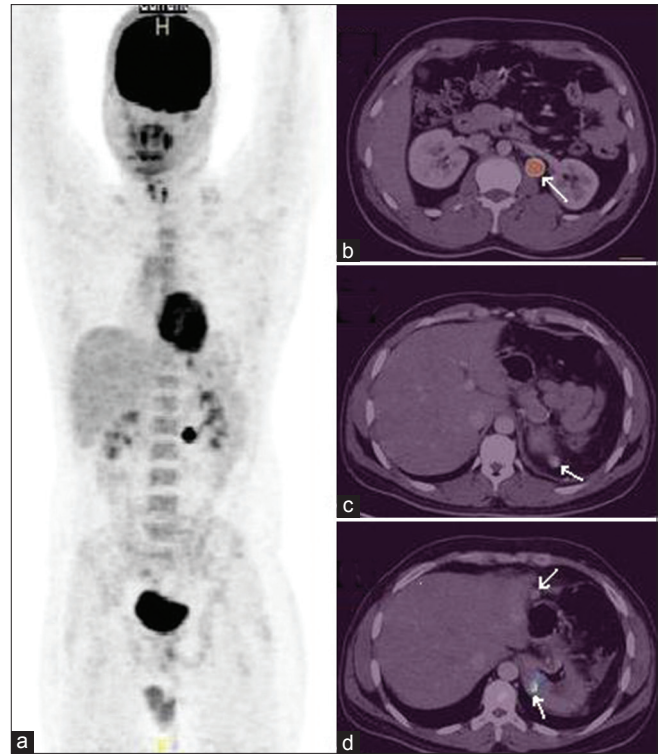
Whole body fluorodeoxyglucose-positron emission tomography (PET)/computed tomography (CT) maximum intensity projection image (a), Fused PET/CT showing intense tracer uptake in the paraaortic lymph nodes (b), but mild grade uptake in the deposits (c and d) (arrows)
